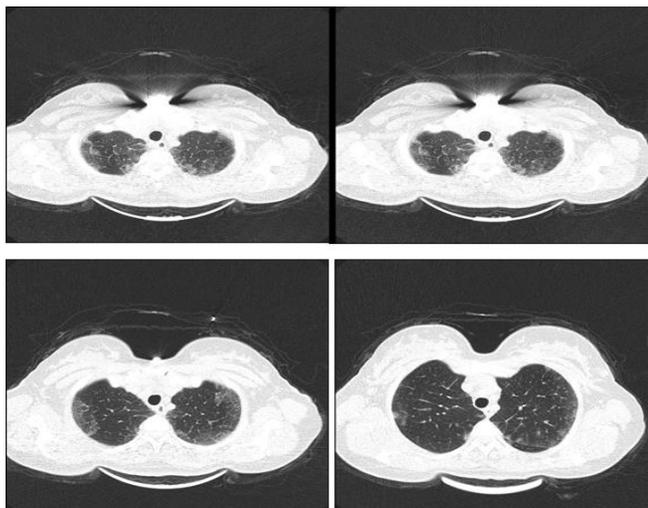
Axial CT image of the patient from 2020, showing bilateral pleural-based ground glass and consolidation areas. A CT axial view of the patient showing the bilateral pleural-based ground-glass appearance and consolidation areas
